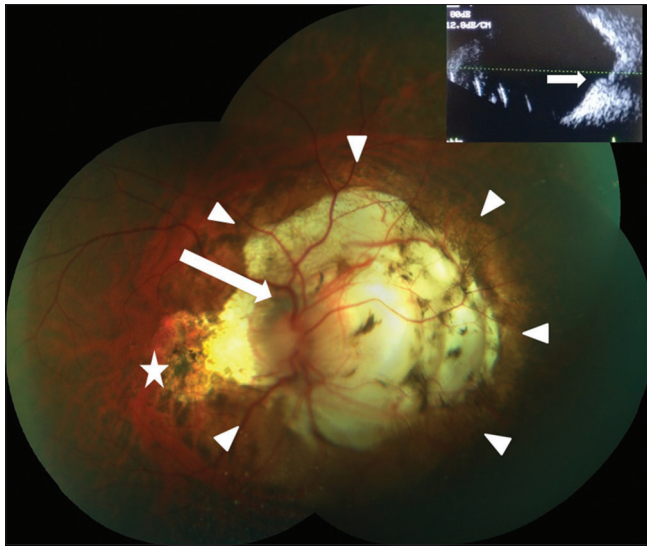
Fundus photo montage of an eye with posterior staphyloma detected to have the posterior hump. The border of the staphyloma can be visualized (white arrowheads) along with myopic maculopathy (white star). The optic disc is seen to be tilted (white arrow). Inset is the ultrasound image of this eye and the “pseudo-hump” has been indicated with white arrow
